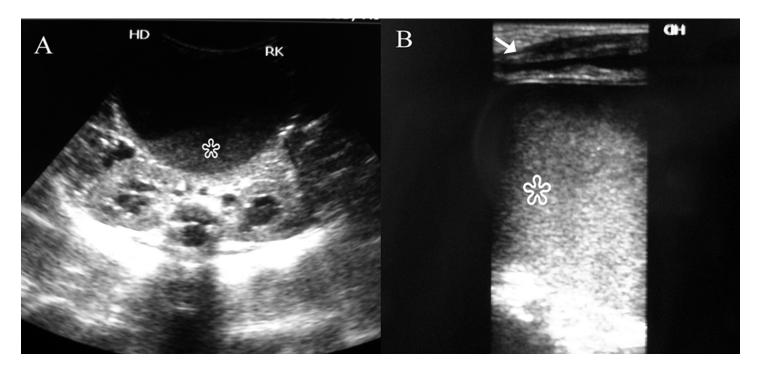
Axial Ultrasound (A and B) demonstrates a large abdomino-pelvic mass lesion with mobile internal debris (asterisk). Mass is causing bilateral moderate hydronephrosis. Note the presence of collapsed bladder anteriorly (arrow).
